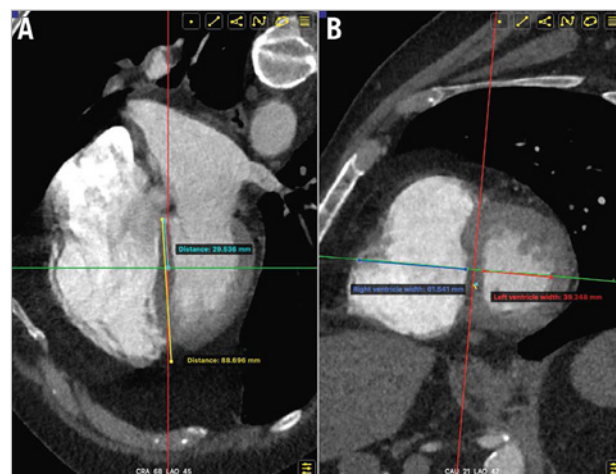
RV and LV measurements via CTA. A) Identification of the basal one-third of the interventricular septum in the four-chamber view. B) Measurement of RV and LV diameters in the plane perpendicular to the mid-septum on both the short-axis and four-chamber views. CTA: computed tomography angiography; LV: left ventricle; RV: right ventricle
